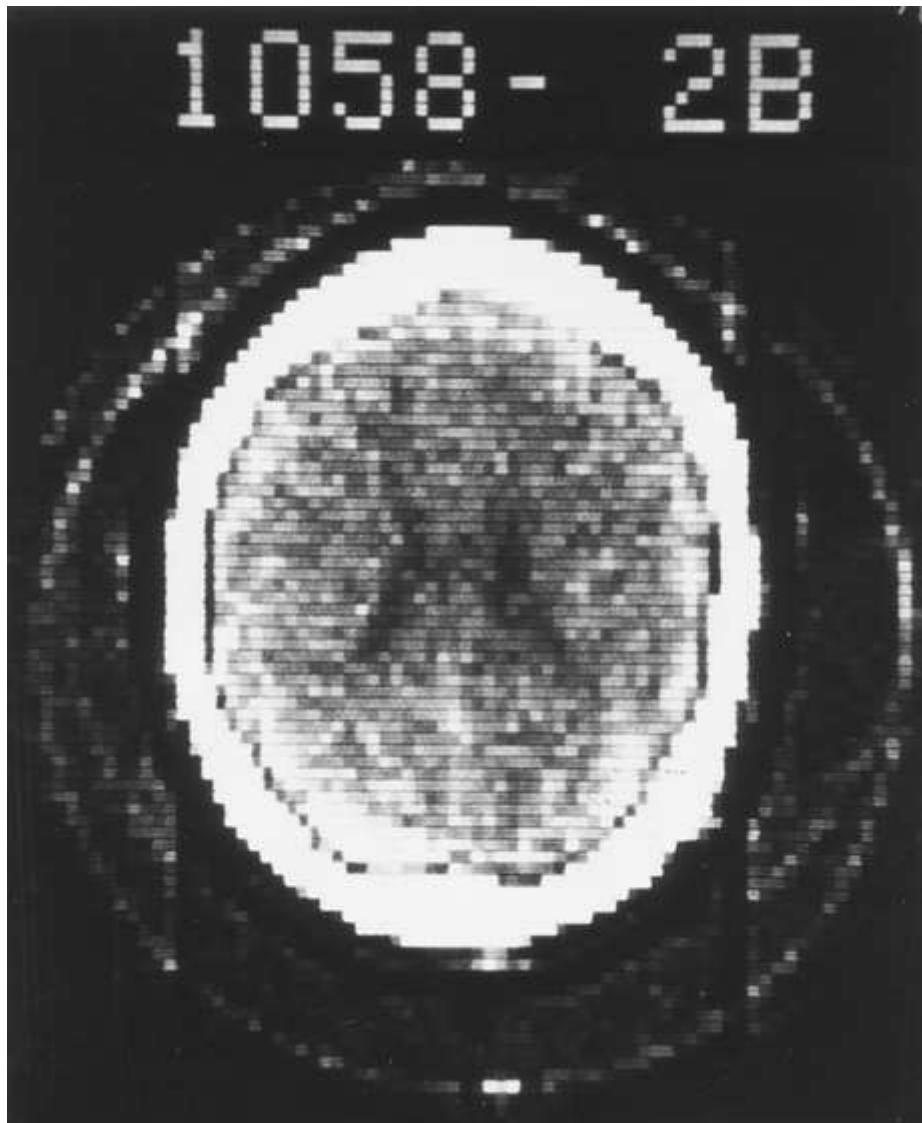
Axial brain image from the first CT scanner in operation in the United States: Mayo Clinic, Rochester, Minnesota. The 80×80 matrix produced a noisy image. The examination was performed in July 1973.
